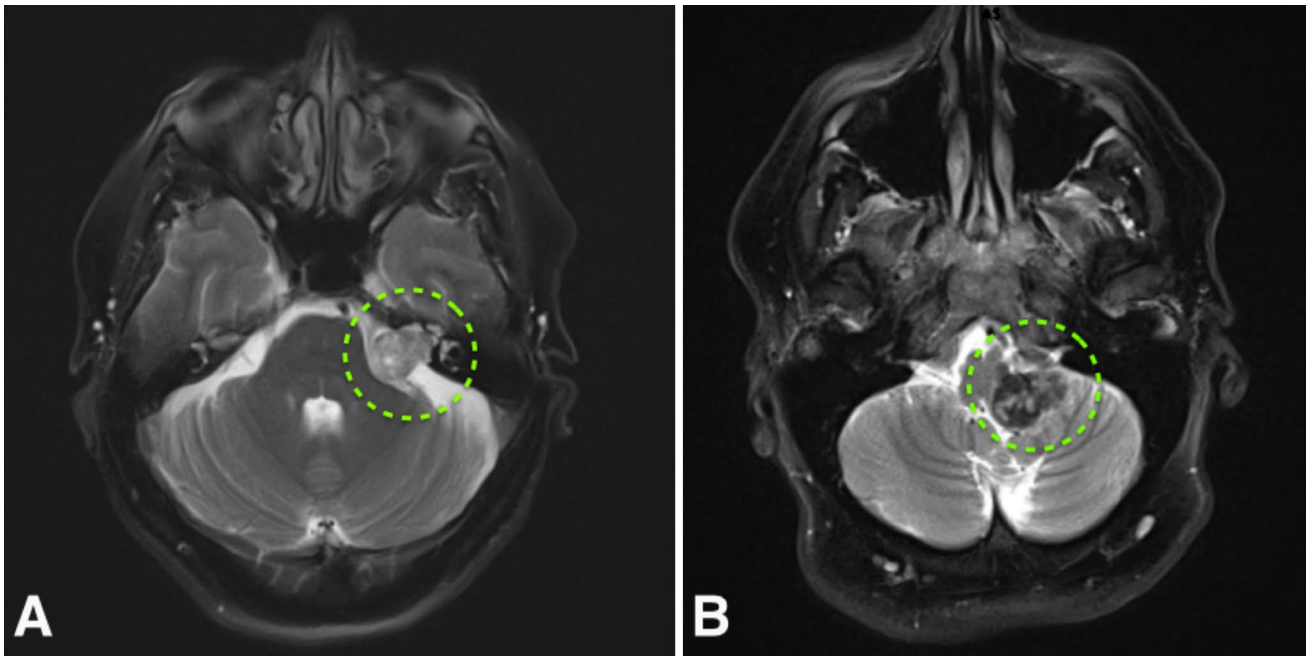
a Schwannoma in left CPA with classical T2 iso-hyperintensity, while b shows an intracranial melanotic schwannoma that displays T2 iso-hypointense radiographical features. CPA cerebellopontine angle
